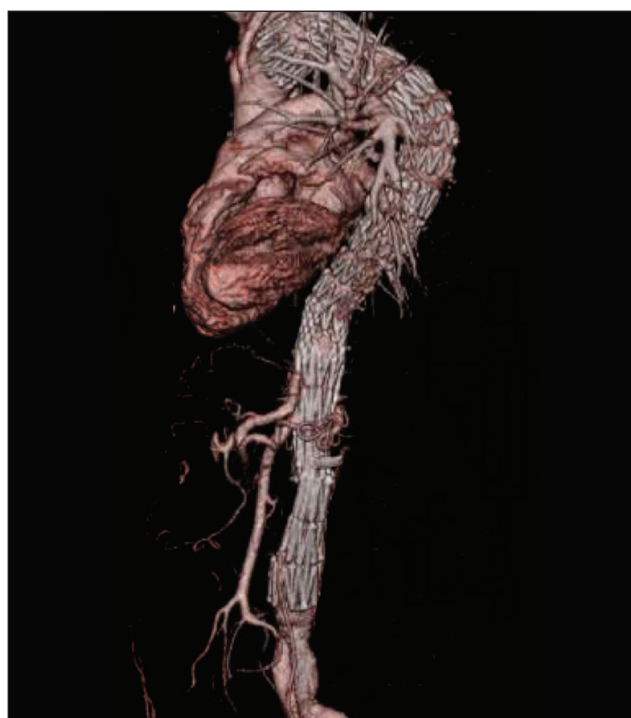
STABLE: Staged aortic and branch vessel endolumenal repair for aortic dissection. Ten-year follow-up computed tomographic angiography. Complicated type B dissection was treated with a TX2 endograft and distal dissection stents, in conjunction with branch vessel-covered stent repair.
